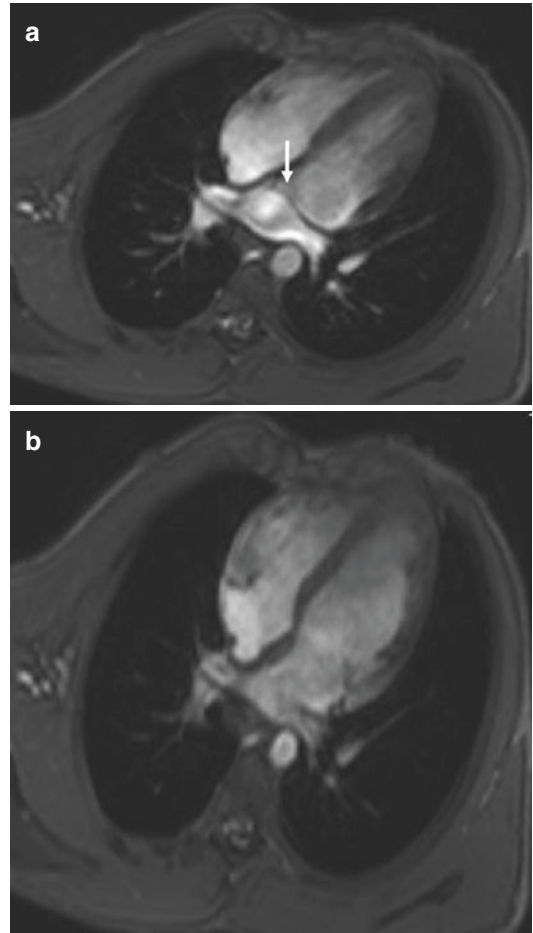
Non-obstructive cor triatriatum at MRI. (a), (b) Four-chamber view images obtained from cine TruFISP MRI sequence show a membrane (*white arrow*) dividing the left atrium into proximal and distal chambers. During the cardiac cycle, a large opening was demonstrated through the membrane
